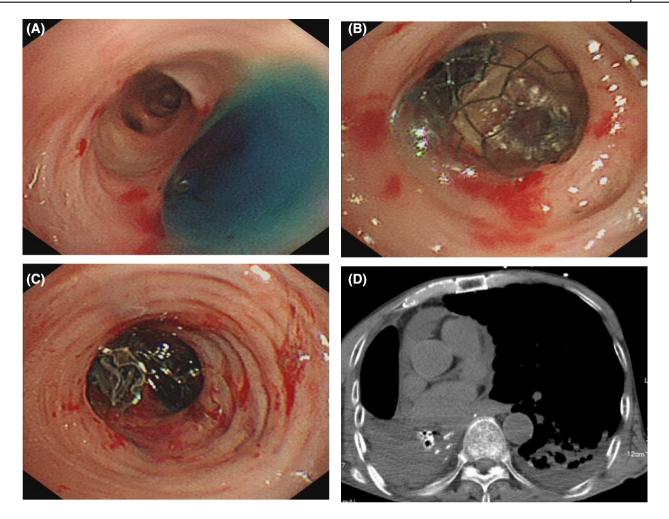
Case 2: (A) After retrograde instillation of 50 mL MB into the pleural cavity, the dye entered the airway from RB4. (B) A version 4.0 EBV was placed in reverse position in RB4 (right bronchus) with the edge of EBV covering RB5 (left bronchus). Another 50 mL MB solution was injected into the pleural cavity, and the dye entered the airway from RB5. (C) The reversely placed version 4.0 EBV was removed and repositioned forward into RB4 (right bronchus). Another EBV of version 5.5 was deployed into RB5 (left bronchus). (D) After deployment of EBV, a chest computed tomography scan showed pulmonary atelectasis in the middle lobe.
